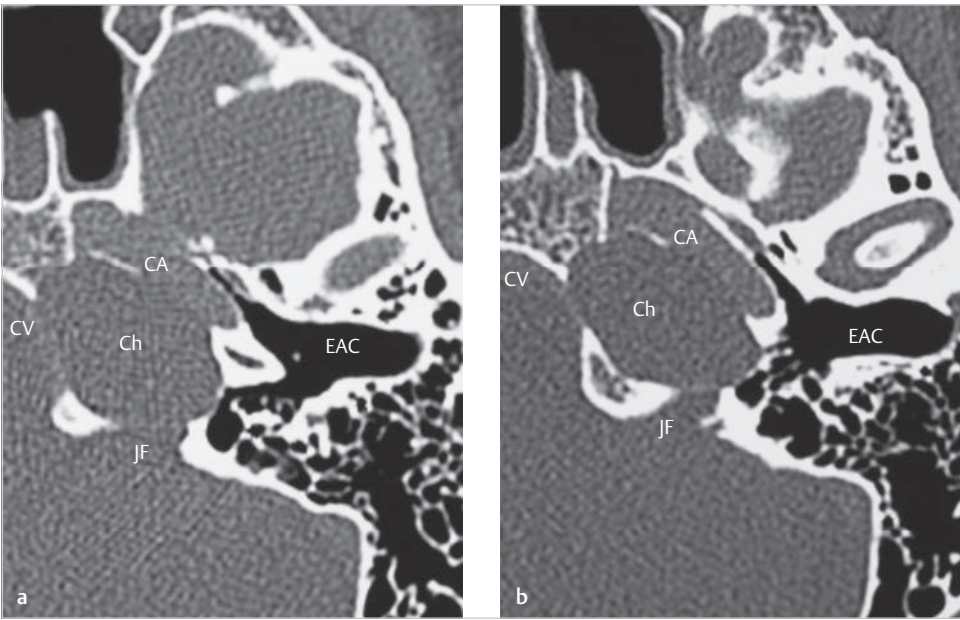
The axial images of CT show erosion of the clivus, the jugular foramen, and the carotid canal. C, cochlea; CA, carotid artery; Ch, cholesteatoma; CV, clivus; EAC, external auditory canal; JF, jugular foramen.
